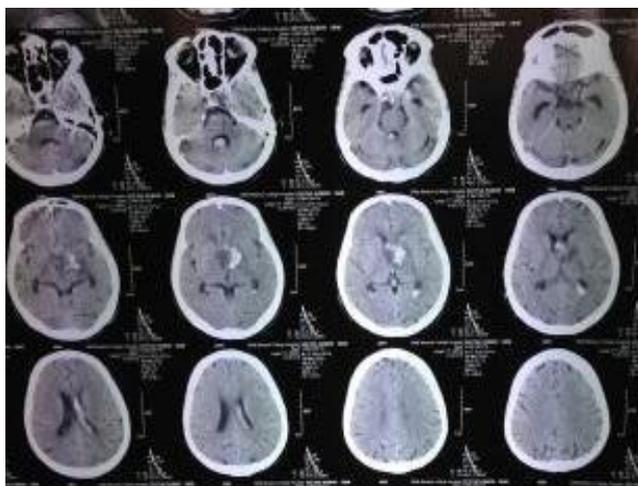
CT Brain showing hypodense lesion anterior to midbrain with hemorrhage in lateral ventricle
